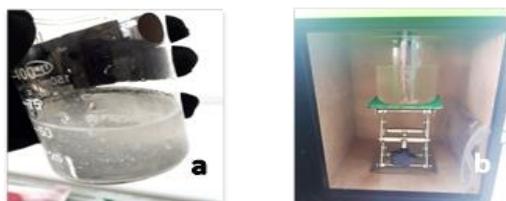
(a) Chitosan is in gel form after being dissolved with glacial acetic acid, (b) Ultrasound dispersion of chitosan gel
